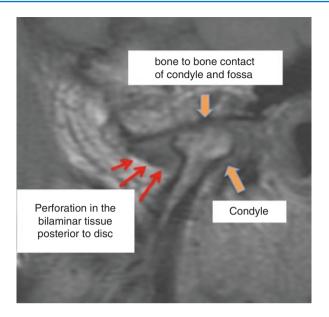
MRI of left arthritic condyle with perforation of the bilaminar tissue posterior to the anteriorly displaced disc. Bone-to-bone contact of the condyle and fossa is observed with crepitation on jaw function
